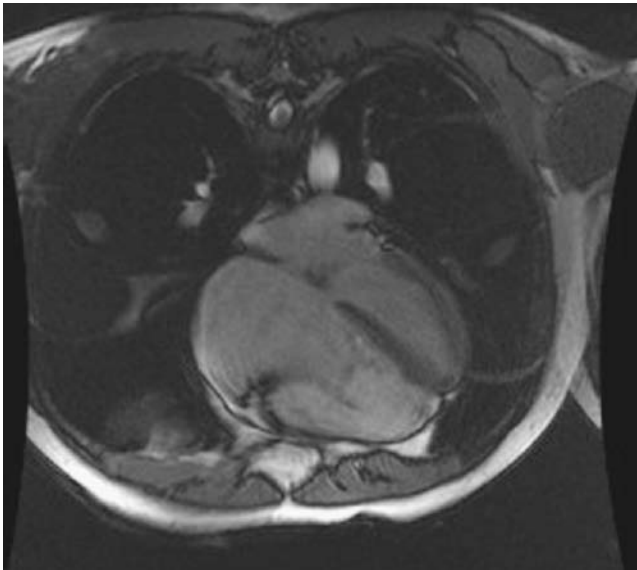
Axial bright blood cardiac magnetic resonance image from the patient presented demonstrates characteristic apical displacement of the septal tricuspid valve leaflet, as well as marked right-sided cardiac chamber enlargement. The measured right ventricular end-diastolic volume was 435 mL. Moderate reduction of right ventricular systolic function was noted. The left ventricle is D-shaped due to volume overload of the right ventricle. The left ventricular function was preserved.
